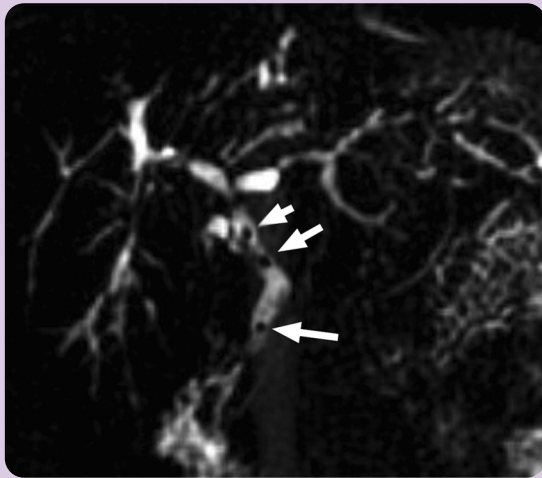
Multiple common bile duct stones are depicted on this coronal thick section T2-weighted SSFSE MRCP image (arrows).
